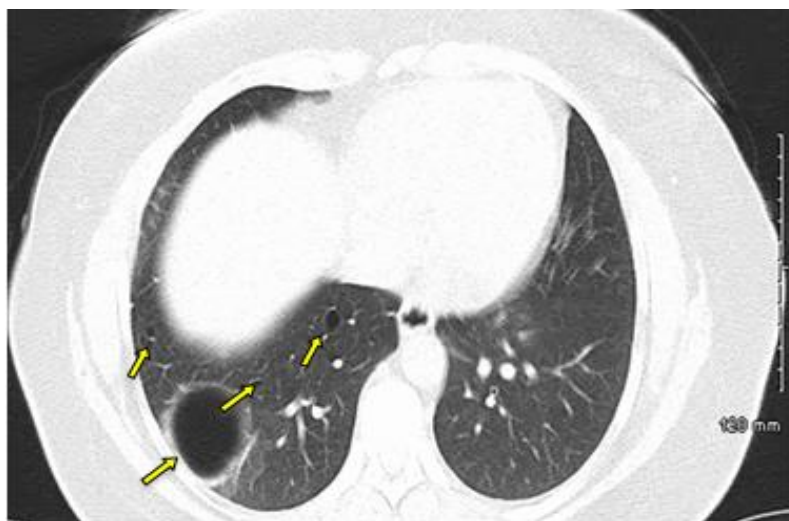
Chest CT showing multiple bilateral thin-walled lung cysts (arrows) consistent with the diagnosis of Birt-Hogg-Dubé syndrome the largest of these is in the posterior basal right lower lobe and measures 5.8 cm in diameter.
